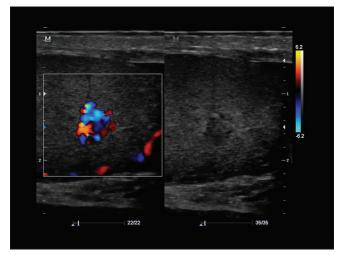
Ultrasound revealed a hypoechoic mass and color Doppler showed the vascular nature of the lesion
